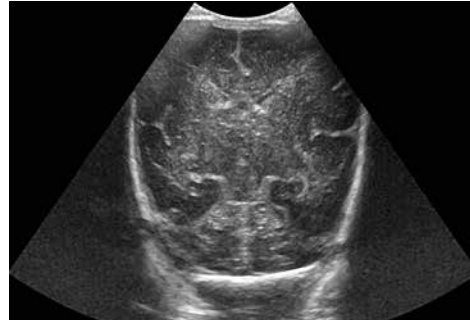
Coronal ultrasound scan at the level of the bodies of the lateral ventricles, performed with convex transducer, showing a good near-field resolution. The far-field resolution is superior to that of the phased array transducer (preterm infant, gestational age 27 wk).
